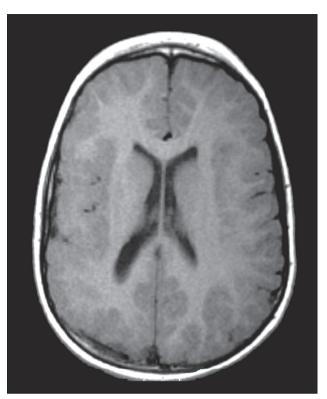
T1-weighted MRI sequence showing right hemisphere atrophy with PMG in the left parieto-occipital cortex in a 9-year-old boy.
